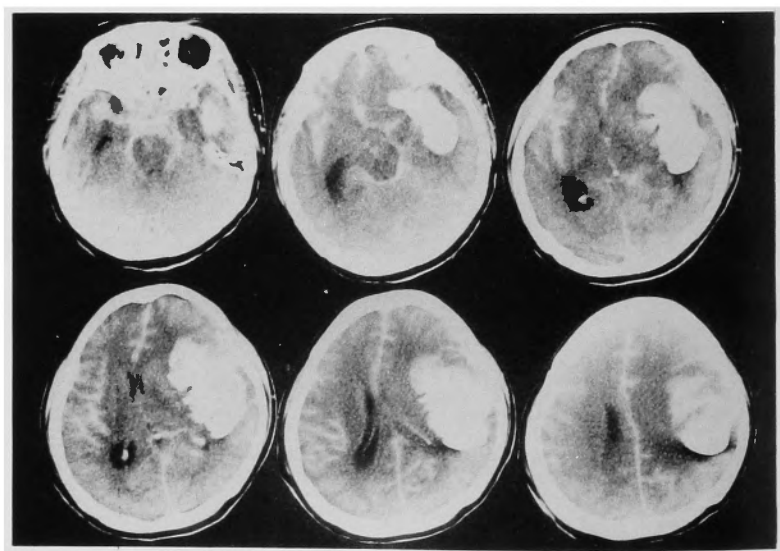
Post-angiographic CT scan showing an increase in the extent of the hyperdense area in the right Sylvian fissure, due to enlargement of the hematoma and extravasation of contrast medium.
